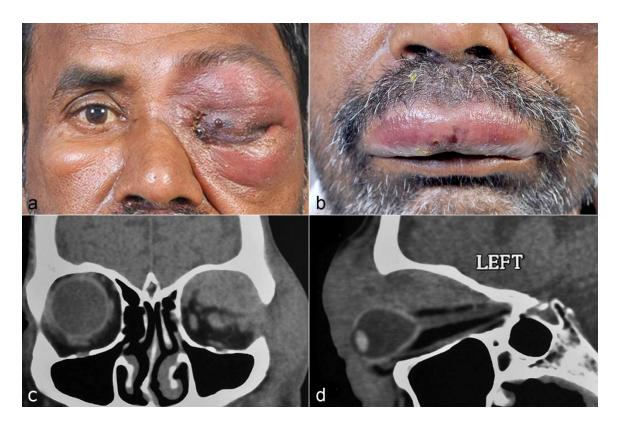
External photograph of the patient showing left periocular edema with total ptosis, skin induration and blisters (Fig 4a). External photograph showing upper lip edema with blisters (Fig 4b). CT Scan coronal cut of the same patient shows a diffuse ill-defined mass involving the entire superior orbit with superolateral bony erosion and extension into the temporal fossa (Fig 4c). CT Scan with saggital reconstruction showing diffuse mass involving the entire superior quadrant up to the apex with indentation of the globe and optic nerve stretch (Fig 4d).
